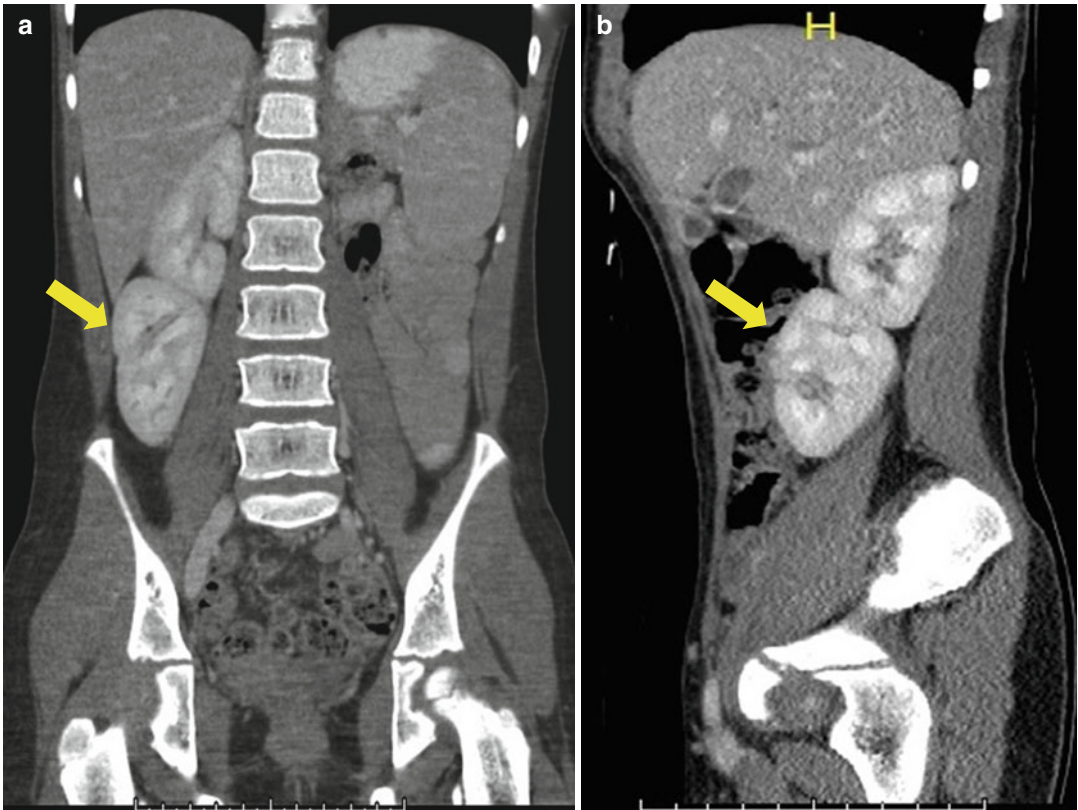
CT scan coronal (a) and sagittal (b) views of a crossed fused renal ectopia. The crossed kidney (yellow arrow) lies underneath the native right kidney
